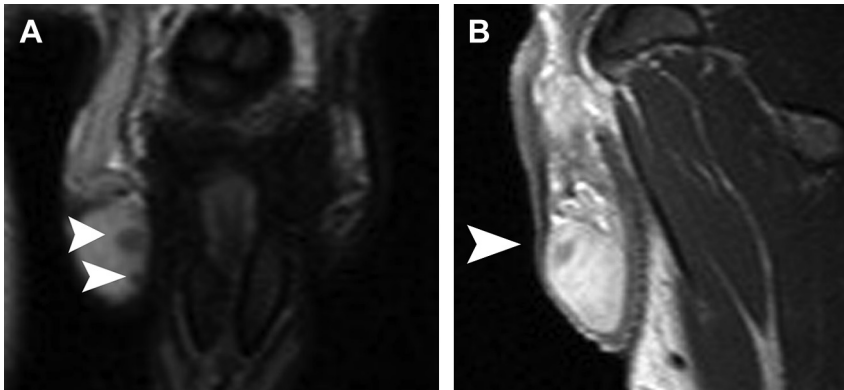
Granulomatous orchitis in a 33-year-old man. (A) Coronal T2-weighted image depicts 2 small-sized right intratesticular mass lesions (*arrowheads*), mainly hypointense. (B) Sagittal postcontrast T1-weighted image shows absence of contrast enhancement (*arrowhead*), a finding suggestive of a benign diagnosis.
